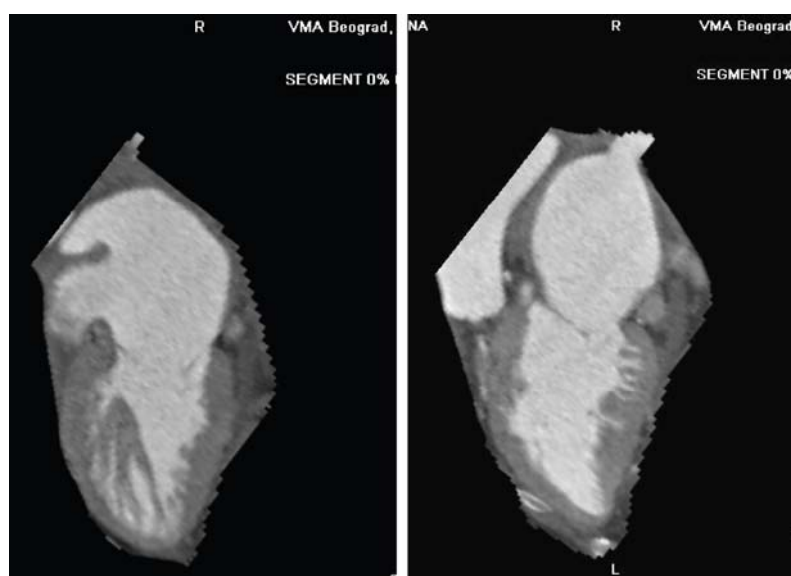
Multislice computed tomography of the heart with left ventricular noncompaction. Multiple trabeculations and recesses between them are visible apically, on lateral and inferior walls.
